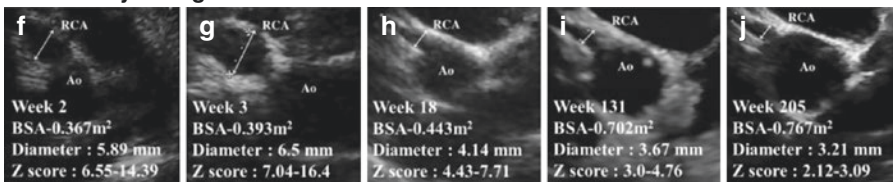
A 5-year-old boy with KD-associated giant aneurysms underwent intravenous methylprednisolone pulse therapy just after acute phase (week 3–4 since KD onset). Serial echocardiography imaging revealed significant regression on both-side aneurysms during week 205 since
